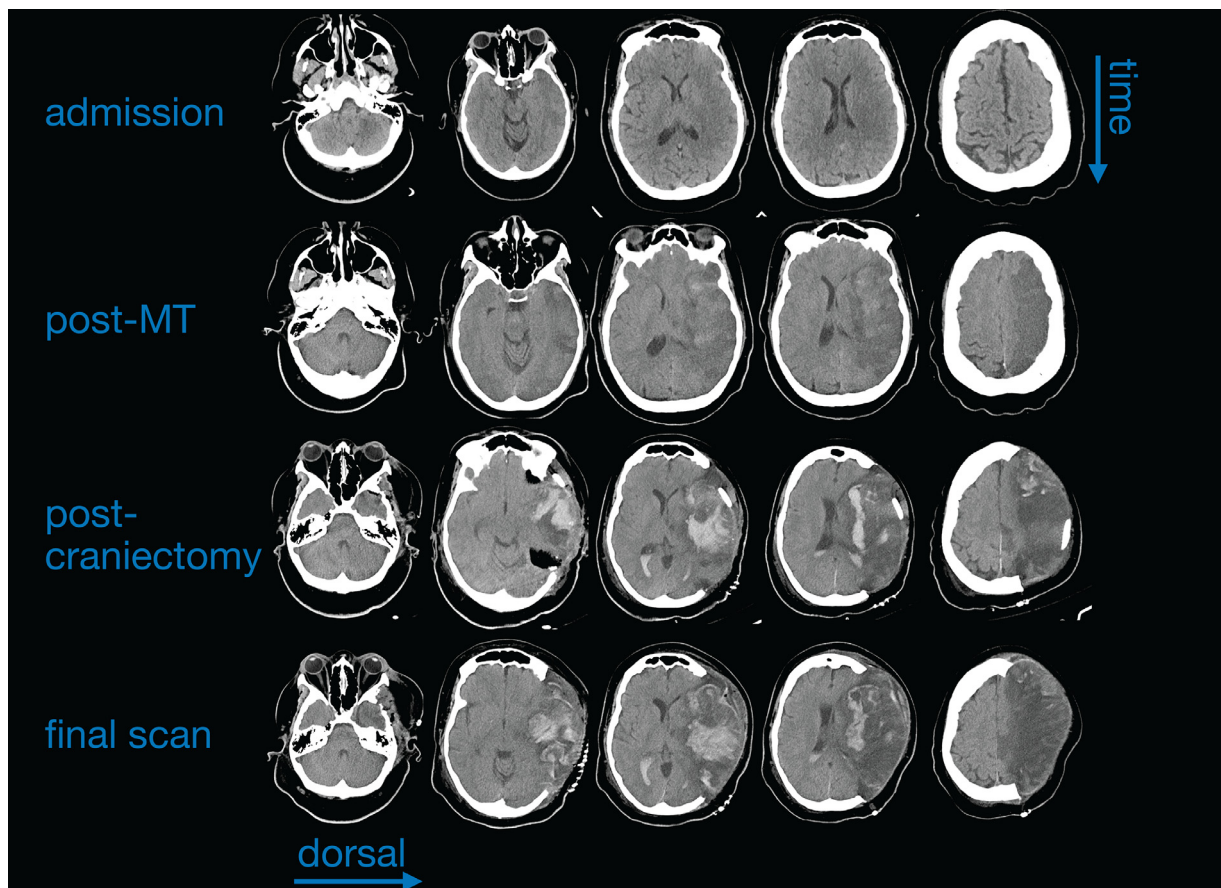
Serial CT images during hospitalization. Four CT studies are shown during the patient's hospitalization, with later studies being lower rows. Similar axial cuts are shown from each studies. Left is most ventral, right is dorsal.
